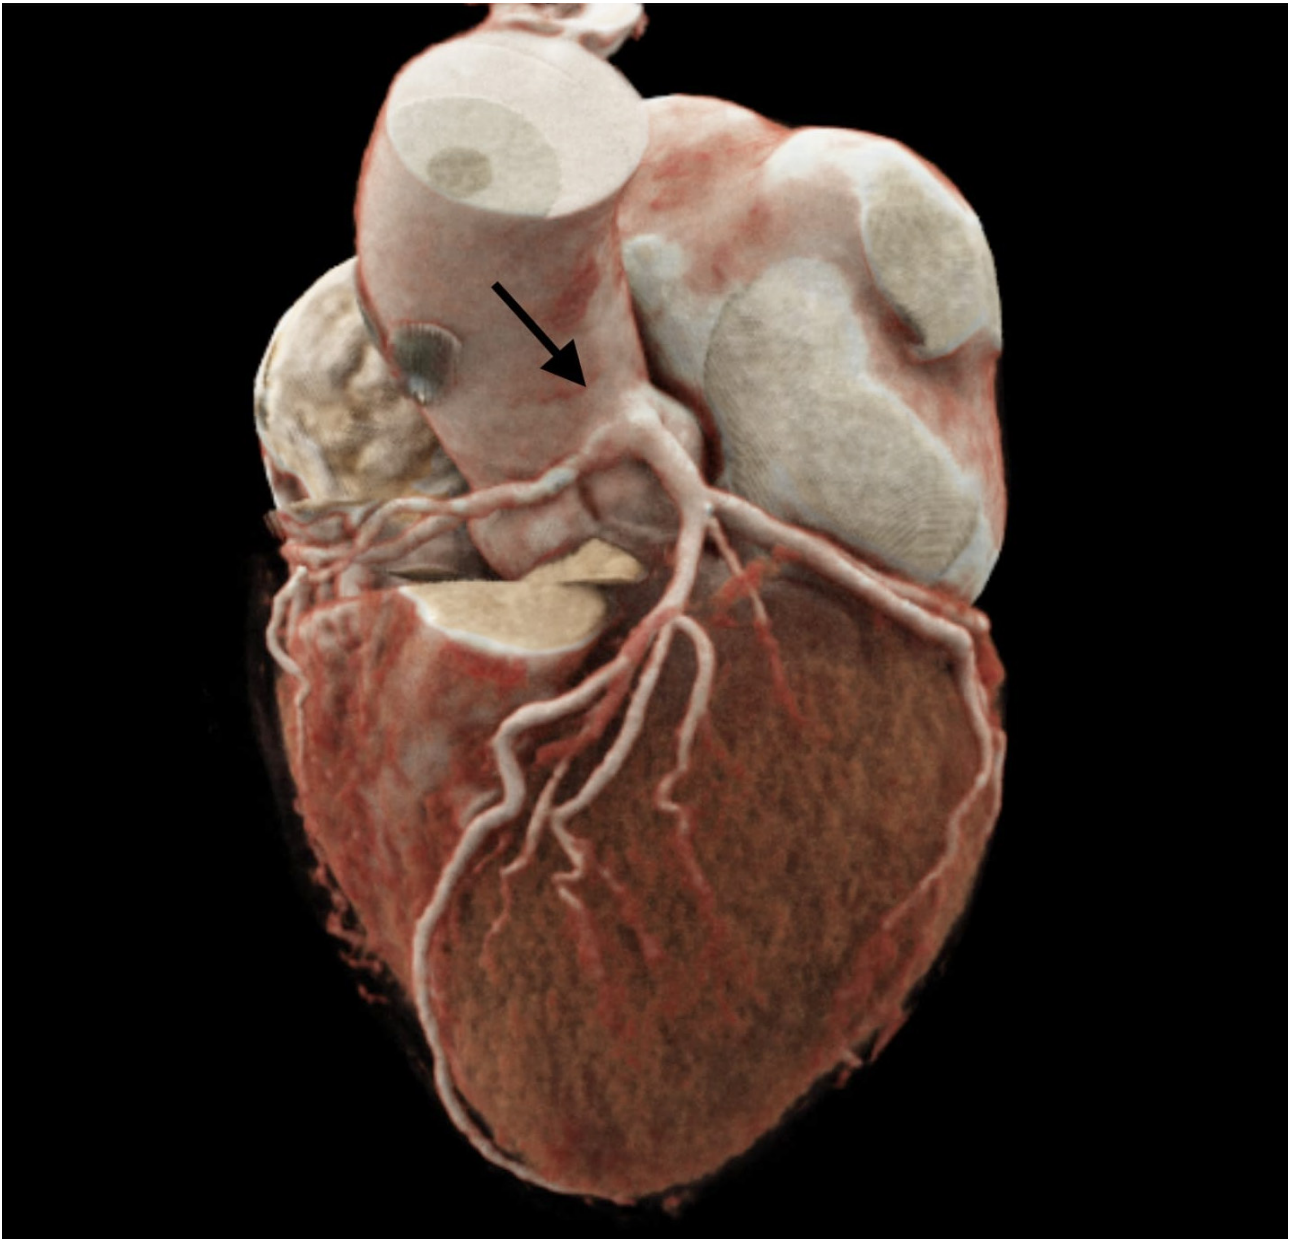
Figure legend: 3D image taken from coronary CT angiography showing anomalous origin and course of RCA.
